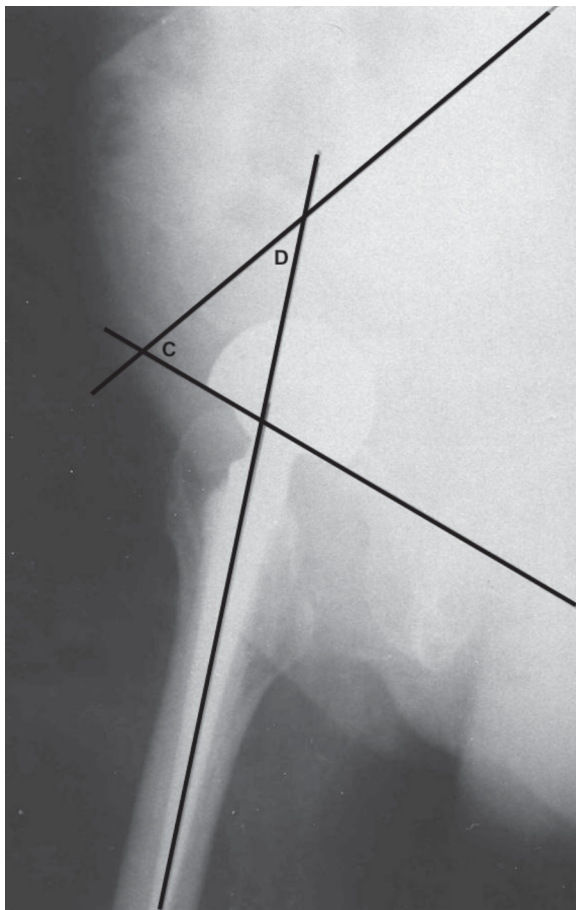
Pelvis X-rays in upright posture and monopod support
